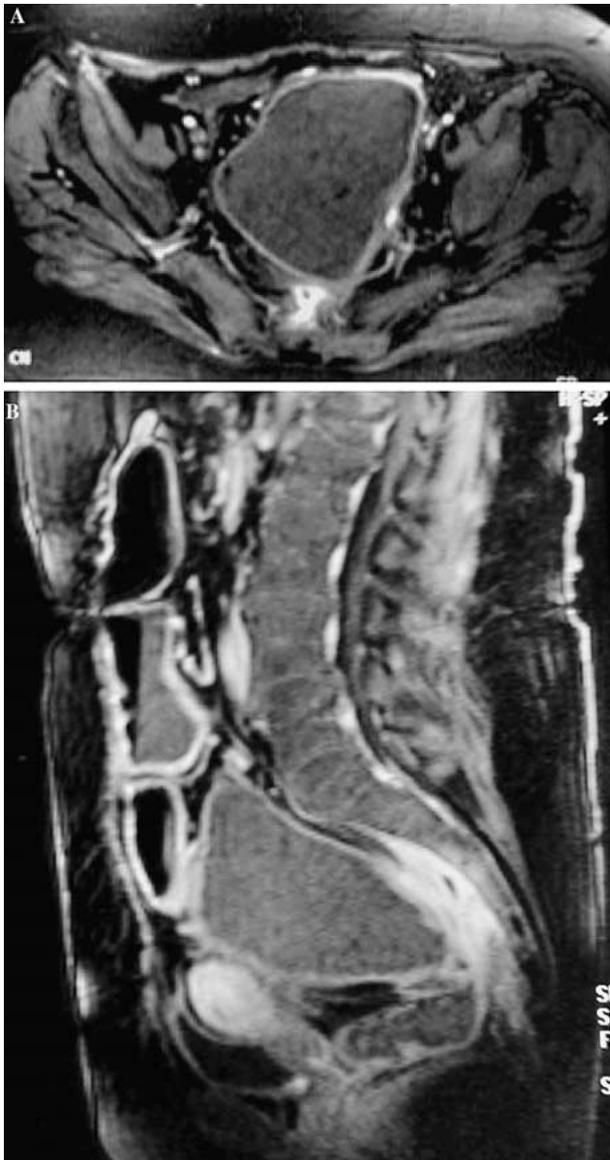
A 70-year-old female after total colectomy for UC, with chronic endoscopic signs of inflammation at the level of the ileal pouch. Axial (A) and sagittal (B) T1-weighted gadolinium-enhanced images show the wide ileal pouch with moderate diffuse wall enhancement and thickness. In the presacral region, strongly enhancing inflammatory tissue is evident, suggesting a fistulous complication.
